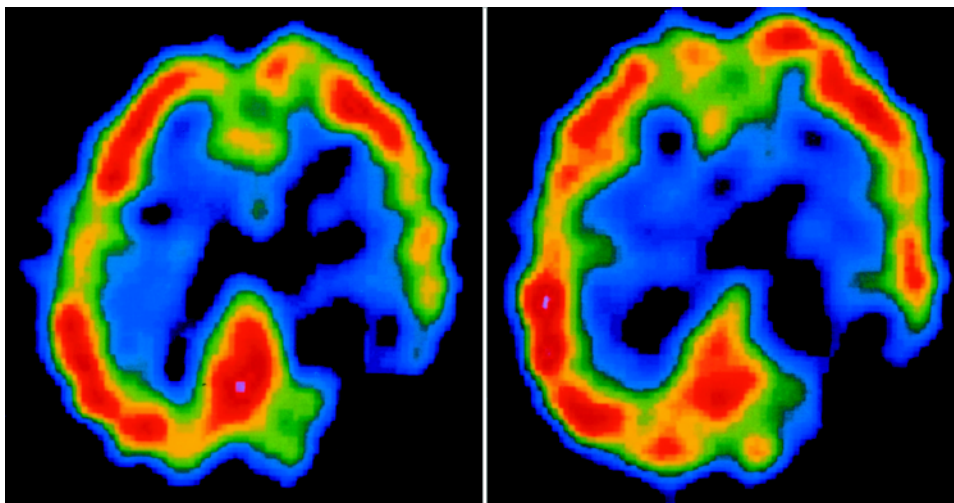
Left:* A ^{123}I -IMP SPECT scan revealing an extensive decrease in CBF in the left temporoparietal lobe. *Right:* A ^{123}I -IMP SPECT scan obtained after treatment, demonstrating an increase in CBF in the temporal lobe.
